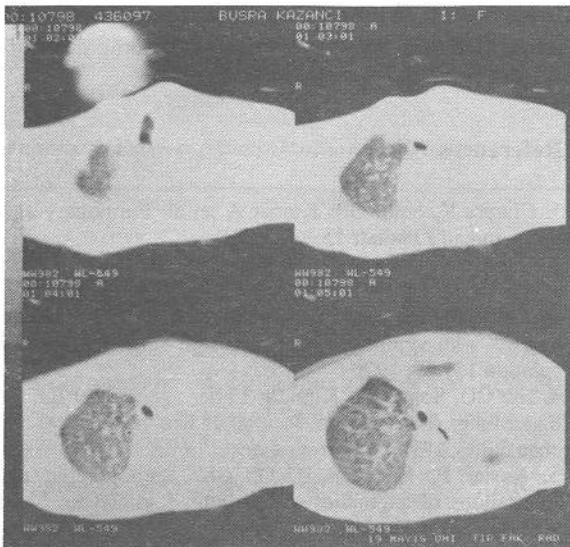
Chest computed tomography examination of the patient after bronchoscopy showing no pulmonary tissue in the left upper hemithorax.
